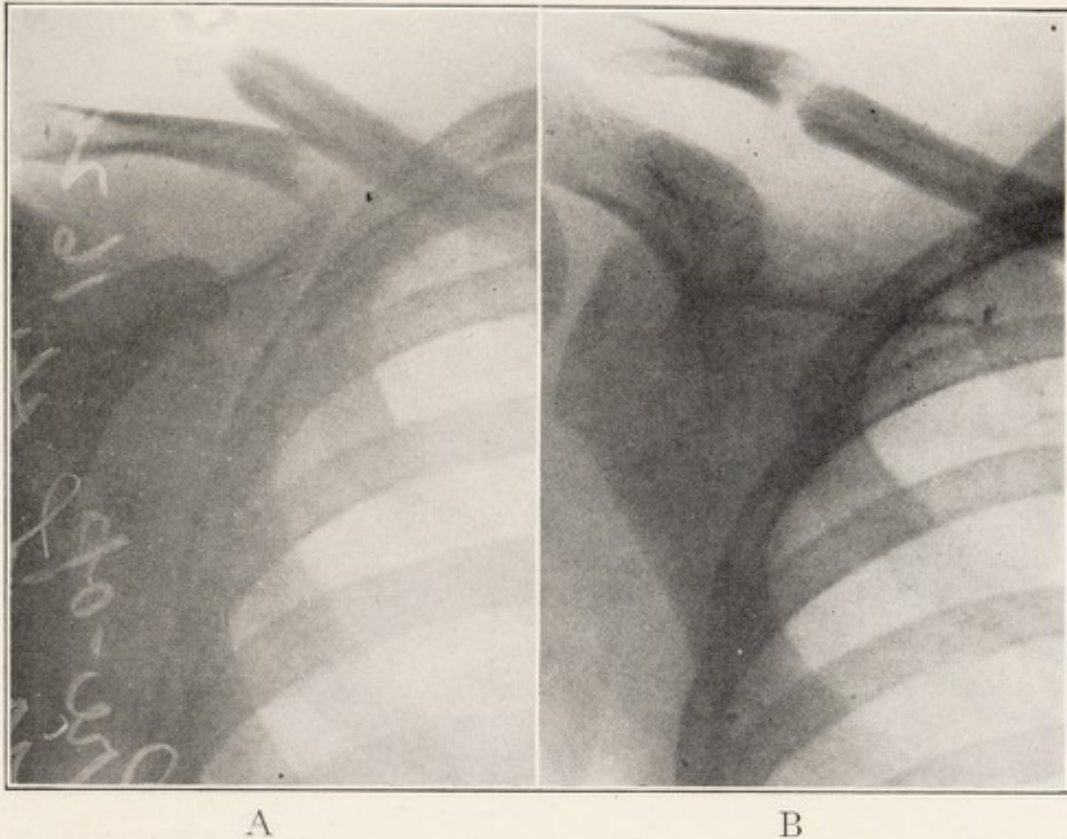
X-RAY OF FRACTURE OF CLAVICLE, JUNCTION OF MIDDLE AND OUTER THIRDS, SHOWING UPWARD DISPLACEMENT AND OVERRIDING OF MEDIAL FRAGMENT.
